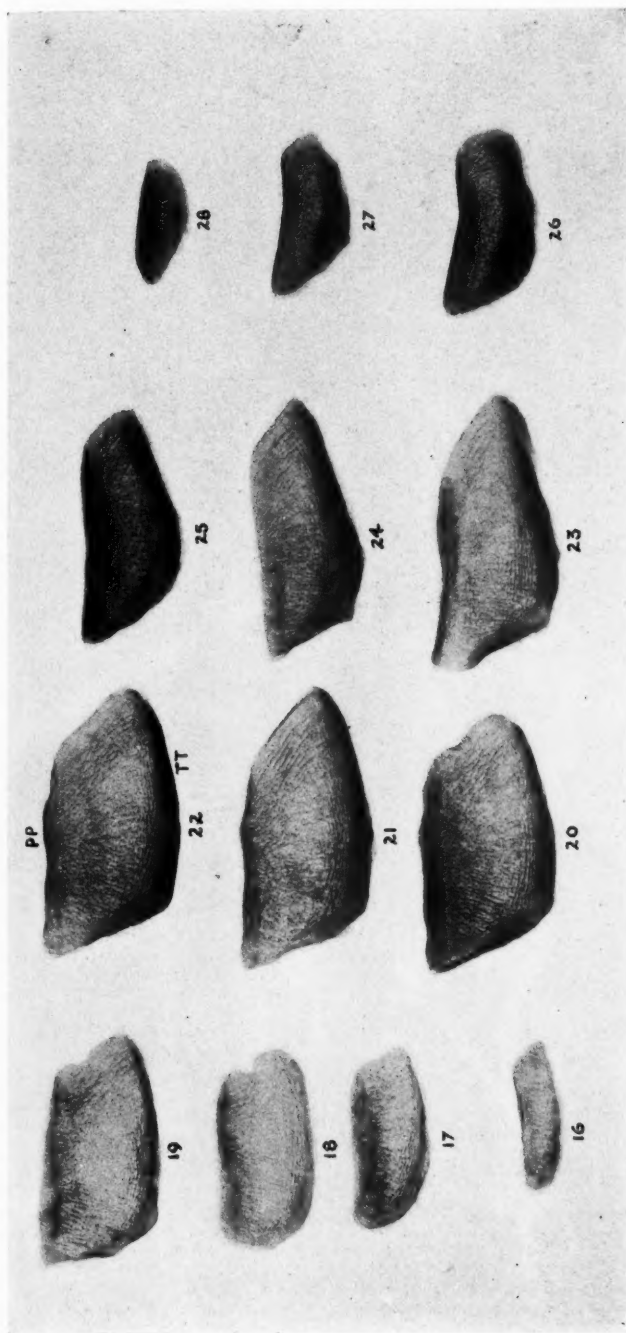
Figs. 16 to 28. Roentgenograms of a single human patella, cut in serial sagittal sections, each section 1 mm. thick. Figure 16 is the medial end of the series and Figure 28, the lateral member of the series. "PP" is at the articular aspect of the patella toward which the pressure pillars converge. "TT" is at the ventral aspect of the patella where the compact traction trabeculae are placed (natural size).
